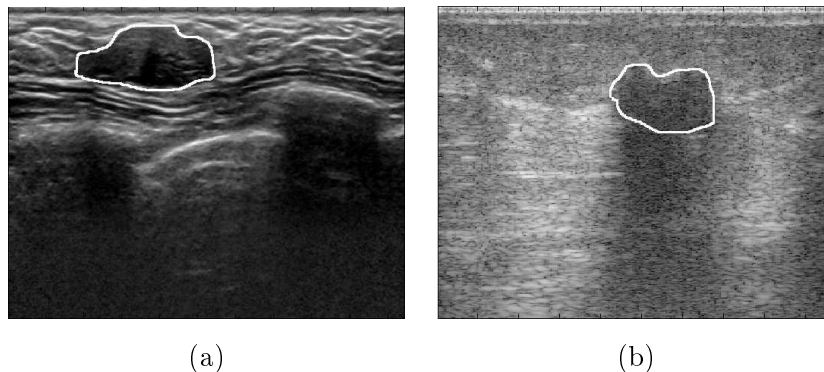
Example of FA and IC lesions. (a) Fibroadenoma lesion in which intensity inhomogeneities within the lesion are present. (b) Invasive carcinoma in which a prominent shadow is formed. The images were acquired from different ultrasound systems. Lesion boundaries have been provided by expert manual delineation.
